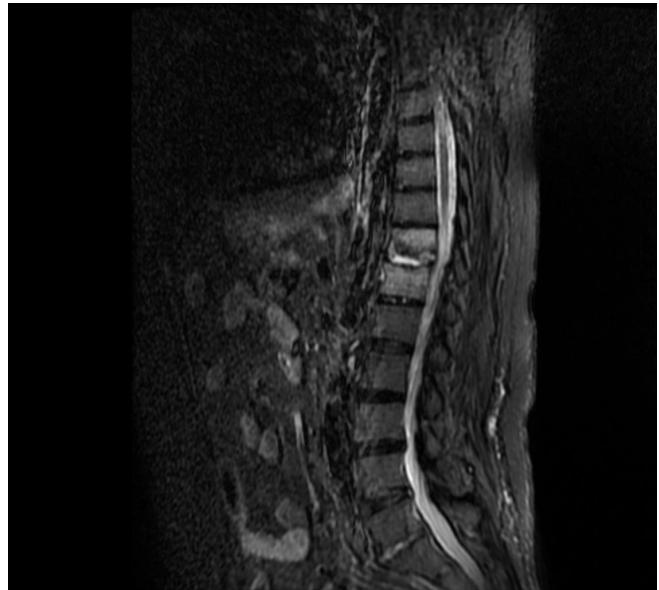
Sagittal stir MRI showing D11-12 lesion.
